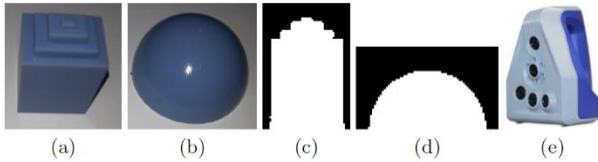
The experiment utilized plastic objects in cubic and dome geometries (a) and (b). All of objects were photographed with an AS Spider TM laser scanner (e). CT image slices are presented in (c) and (d).
